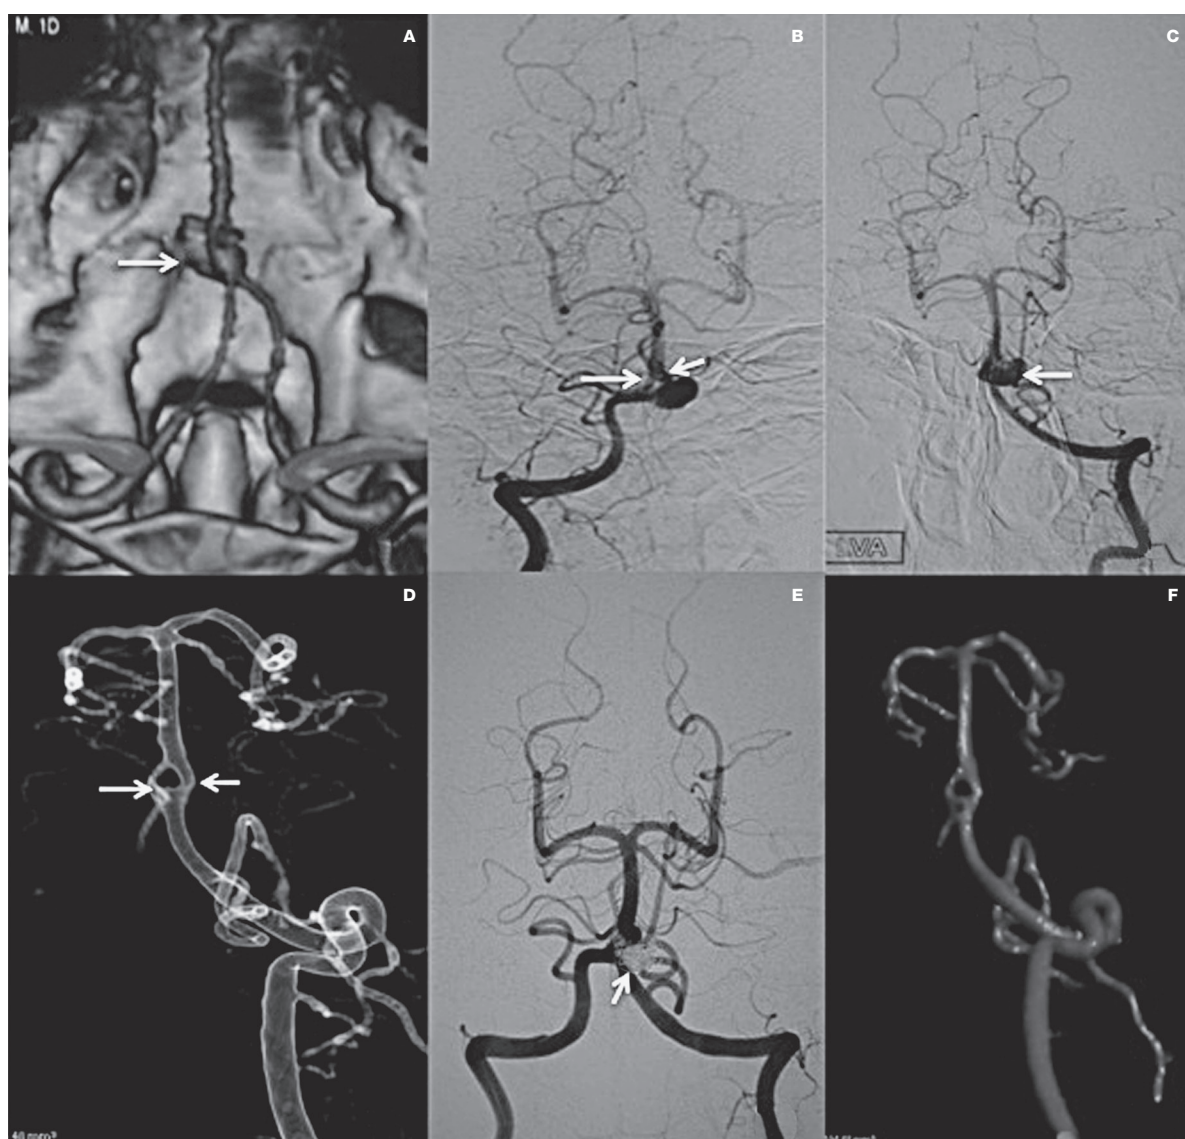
A) Pre procedure CT angiography. B,C) Digital subtraction angiogram of the right (B) and left (C) vertebral artery. D,F) Post procedure 3D rotational angiography. E) Post procedure digital subtraction angiography. A saccular aneurysm can be seen arising from the proximal bifurcation of the fenestration (arrow in A and C). Both limbs of the fenestration are clearly visible (arrows in B). Post procedure images (D,E) show complete obliteration of the aneurysm (arrow in E) with preservation of both limbs (arrows in D).
